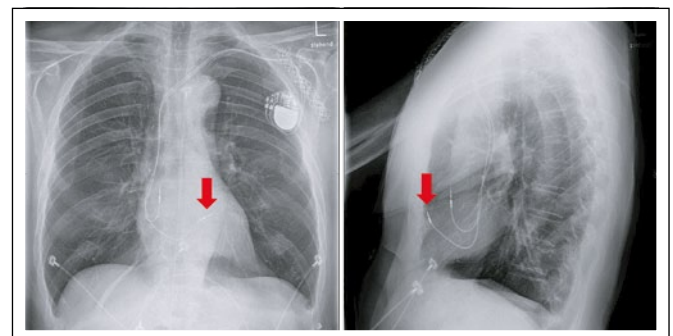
X-ray image of the thorax in posterior-anterior and lateral radiation direction. It shows no pathological signs and the proper position of the pacemaker leads. The high septal ventricular lead is marked by a red arrow.
